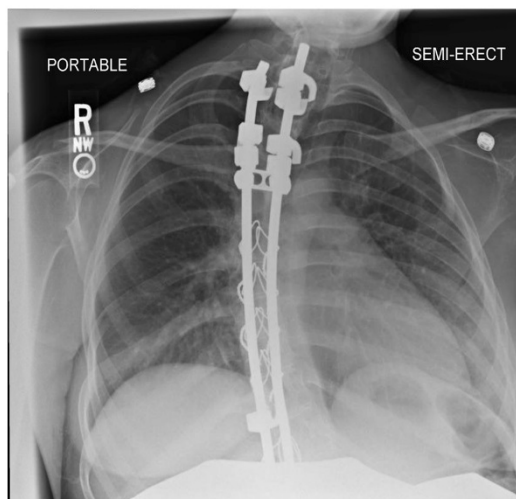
Chest x-ray at 37 weeks gestation.
